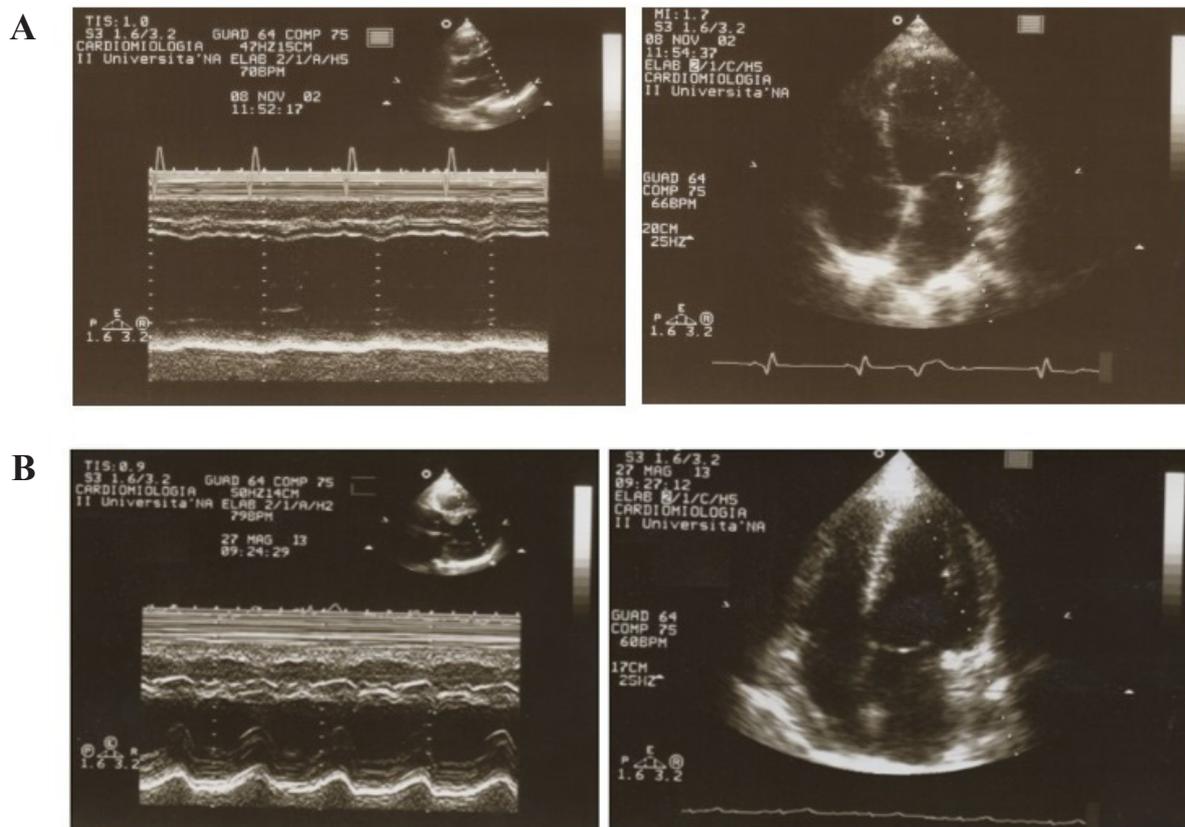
(A) Echocardiography (M-mode scan and apical view of the left ventricle) in the BMD patient (case 2). To be noted: the enlargement of the left atrium (systolic dimension = 48 mm) and the marked left ventricular dilatation (end diastolic diameter = 72 mm); the hypokinesis of the interventricular septum and the virtually absent motion of the left ventricular posterior wall. (B) Echocardiography in the same patient 10 years after heart transplantation. The M-mode scan and the apical view of the left ventricle show normal chamber diameters and ventricular systolic function.
